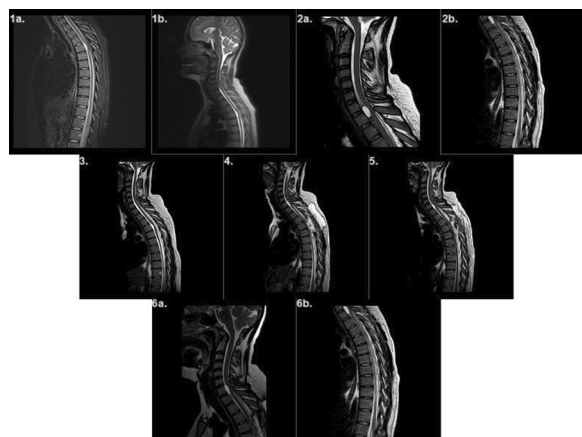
The MRI imaging in T2 sequence: 1a, 1b: Before hospitalization. 2a, 2b: After hospitalization. 3: On the day of surgery. 4: 3 days after. 5: 2 weeks after. 6a, 6b: 1 month after
